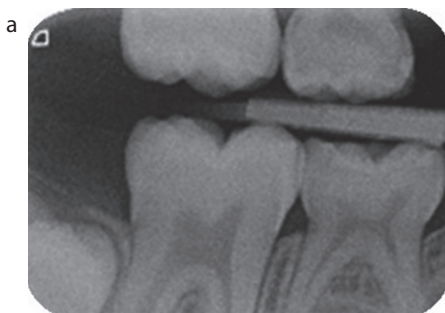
Child did not bite fully onto the tab compromising the bitewing quality.
